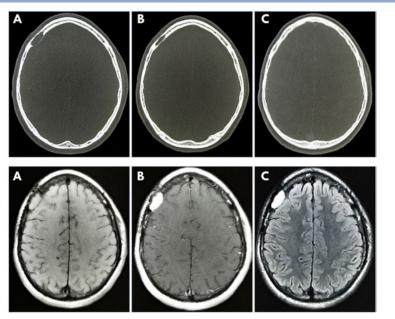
Unenhanced axial CT head bone windows at presentation, (B) eight months prior, (C) four years prior
